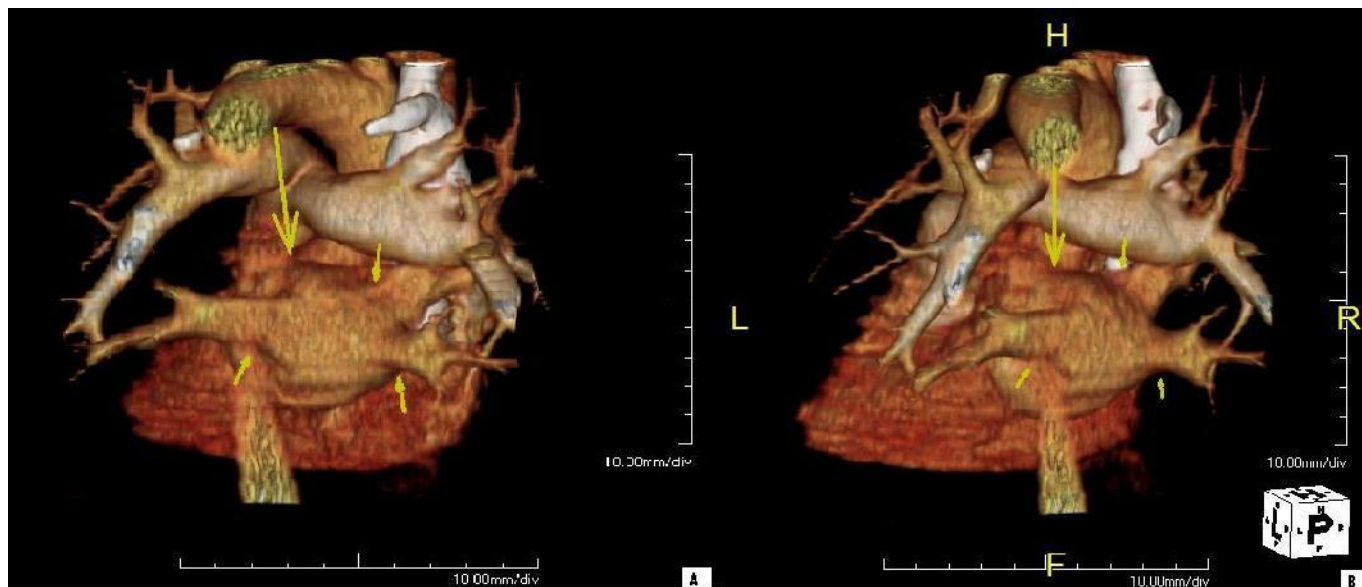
Image A: 66 year old Male with Left Upper Lobe Partial Anomalous Pulmonary Venous Connection. A 3d volume rendered image from a posterior coronal oblique position denotes the normal Pulmonary Veins connecting to the Left Atrium (small arrows). The left upper lobe Pulmonary Vein is not seen connecting to the Left Atrium (large arrow). Image B: A 3d volume rendered image from a posterior coronal oblique position denotes the Normal Pulmonary Veins connecting to the Left Atrium (small arrows). The left upper lobe Pulmonary Vein is not seen connecting to the Left Atrium (large arrow). (Protocol: Phillips CT scanner, 170 mA, 120 kV, 3 mm slice thickness, 100 cc IV of Optiray 300).
